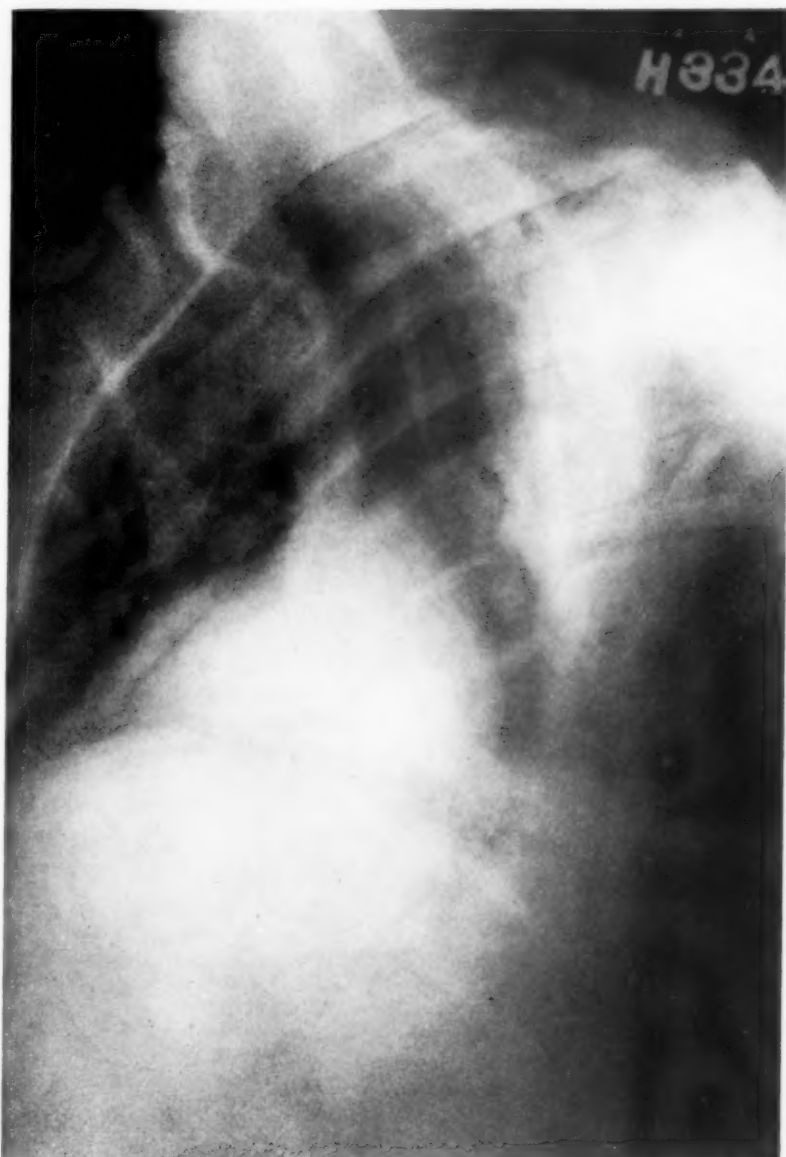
Roentgenogram of heart in the left oblique view. The aortic arch and descending aorta cannot be visualized.
